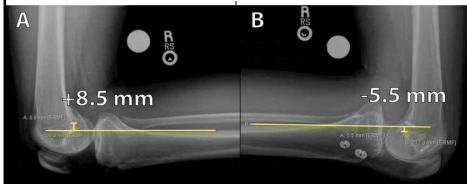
Posterior tibial stress radiographs to measure PTT. Identify a point on the PTC about 15 cm distal to the joint line and draw a line parallel to the PTC. Perpendicular to this line, find the distance between the PTC and the posterior-most aspect of Blumensaat's line. A SSD of 14.0 mm is shown above in a patient who also presented with a concomitant PLC injury. PTT - posterior tibial translation; PTC - posterior tibial cortex; SSD - side-to-side difference; PLC - posterolateral corner
